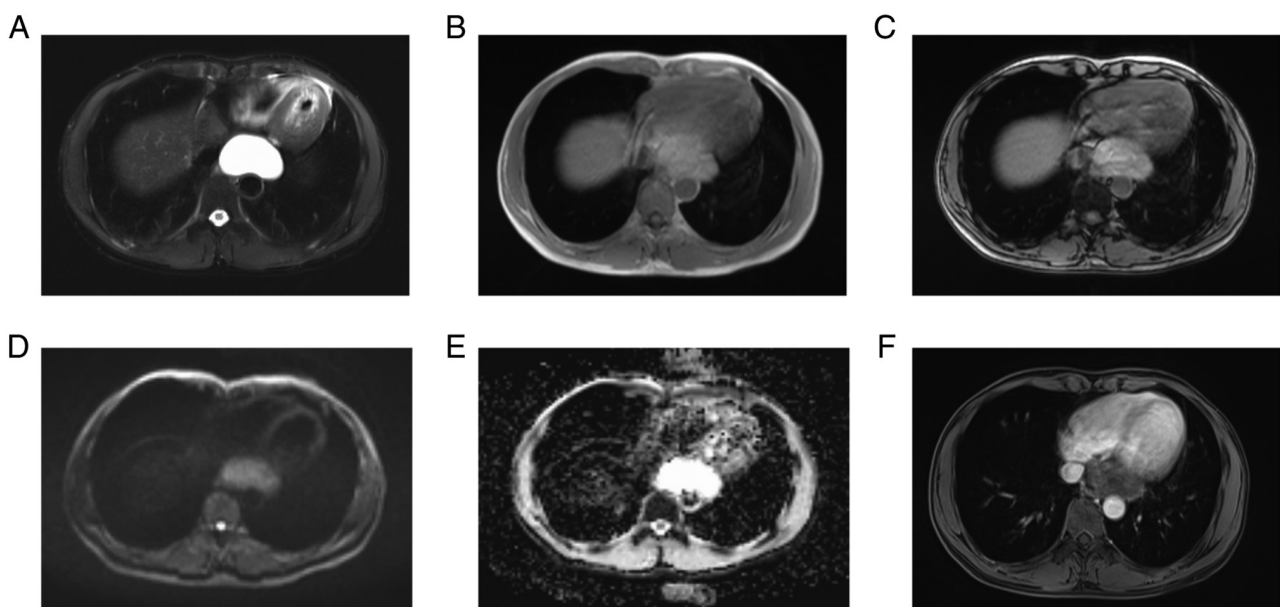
Mediastinal magnetic resonance images of mediastinal cyst. (A) T2-weighted image. (B) T1-weighted image. (C) T1 reverse phase. (D) Diffusion weighted imaging. (E) Apparent diffusion coefficients mapping. (F) Enhanced MRI. MRI, magnetic resonance imaging.
